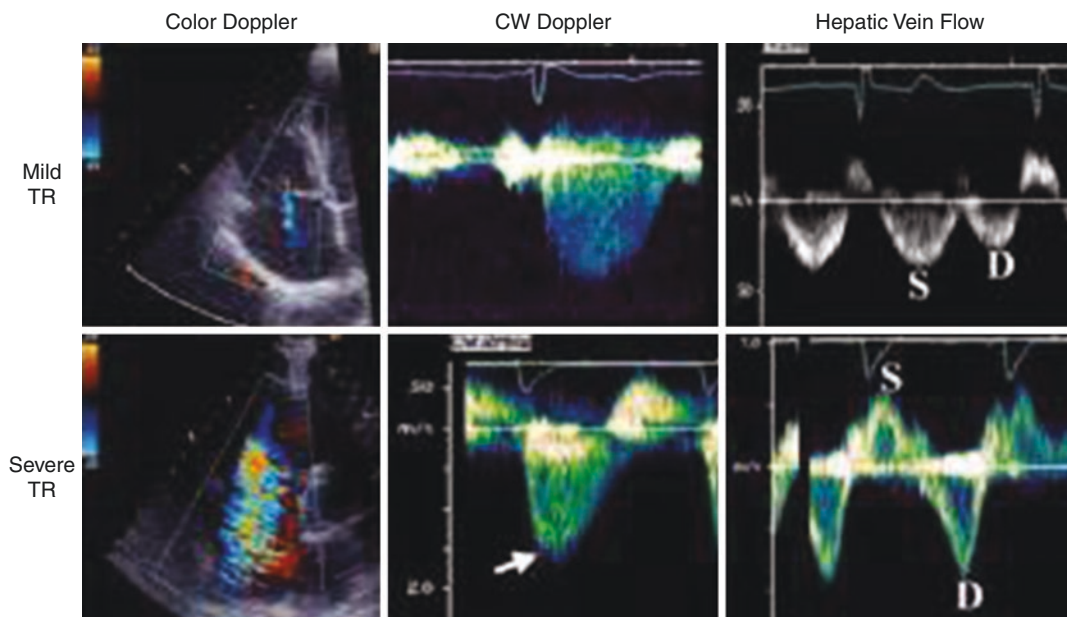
2D echocardiogram demonstrating evaluation of severity of tricuspid regurgitation
